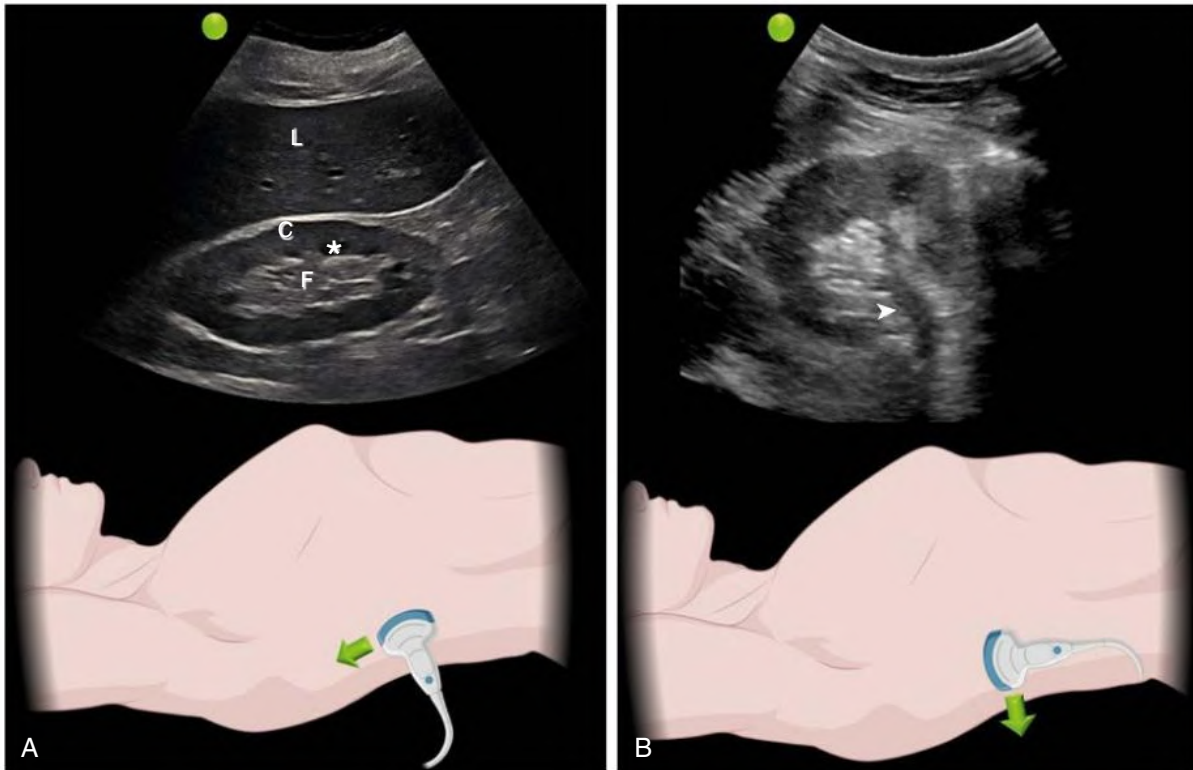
Longitudinal (A) and Transverse (B) Views of a Normal Kidney. The *green arrow* denotes direction of the probe orientation marker during image acquisition. The *asterisk* denotes the medullary pyramid. In the transverse image, the *arrowhead* indicates renal vein (use color Doppler to differentiate from a hydro-ureter). C, Cortex; F, sinus fat; L, liver. (Created with Biorender.com.)
